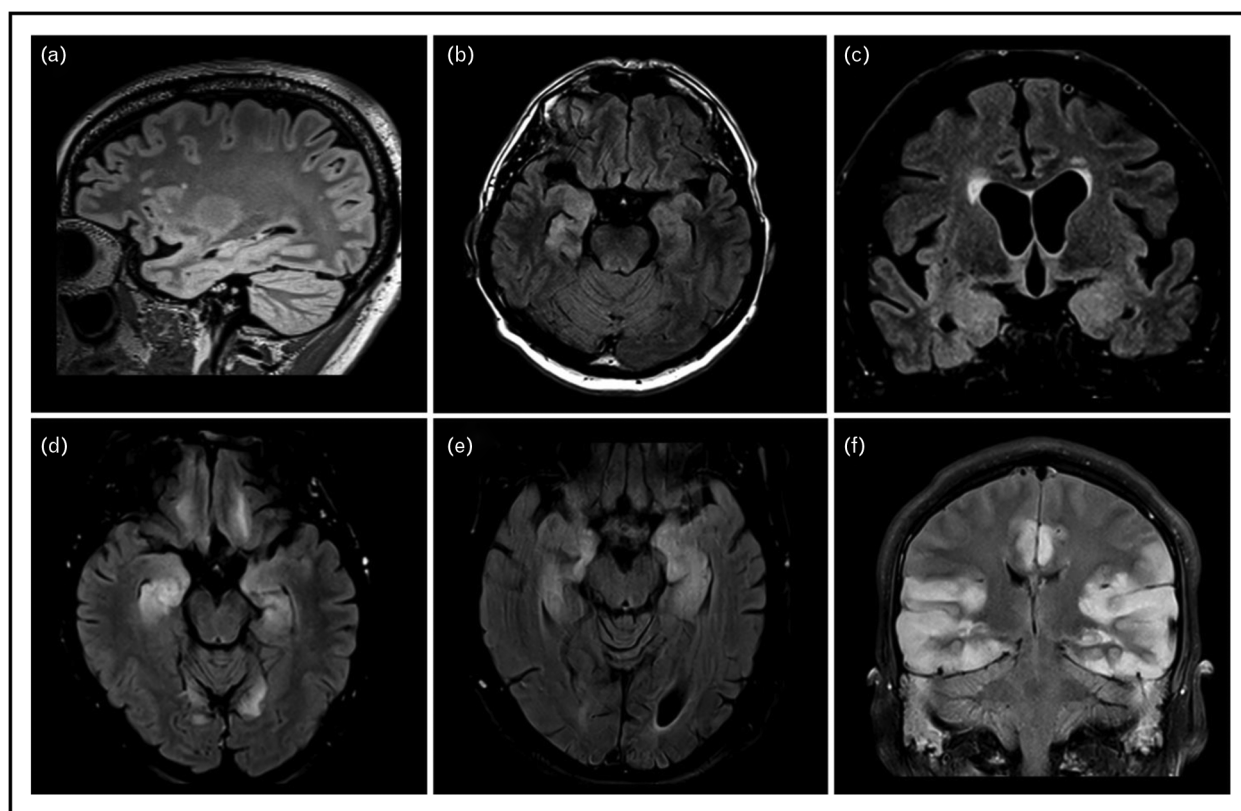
(a) A patient with NMDA receptor encephalitis, with small and nonspecific T2-FLAIR hyperintense lesions in subcortical regions. (b) A patient with LGI1 encephalitis in the limbic encephalitis stage and bilateral medial temporal hyperintensity in T2-FLAIR. (c) A patient with CASPR2 encephalitis and bilateral T2-FLAIR medial temporal hyperintensity and swelling. (d) GAD65 encephalitis patient with T2-FLAIR hyperintense lesions in the medial temporal lobe bilaterally. (e) Patient with GABA(B) receptor encephalitis and bilateral medial temporal hyperintense T2-FLAIR lesions. (f) A patient with GABA(A) receptor encephalitis showing multifocal cortical and subcortical T2-FLAIR hyperintense lesions involving the frontal and temporal lobes, with associated cortical swelling (image courtesy of Prof. Markus Kraemer, Department of Neurology, Alfried Krupp Hospital, Essen, Germany).
